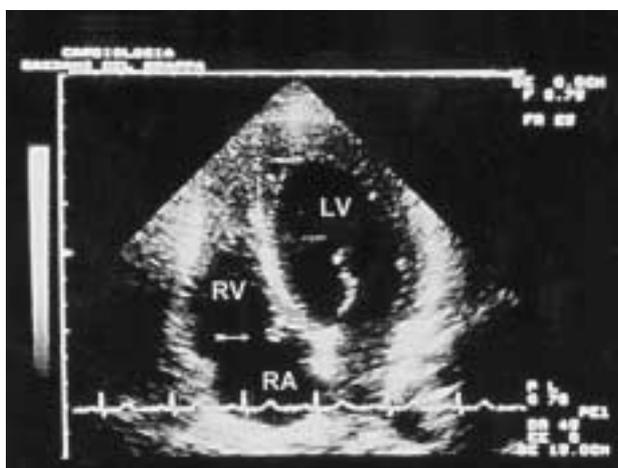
Apical 4-chamber view shows a little fibrous mass (arrow) just below the tricuspid septal leaflet. LV = left ventricle; RA = right atrium; RV = right ventricle.
